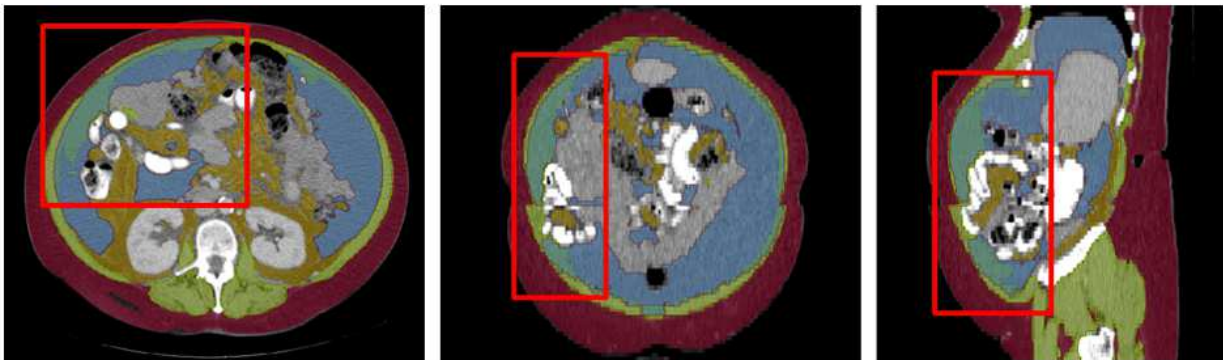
Example segmentations of subcutaneous fat, visceral fat, and muscle on a contrast-enhanced CT image of a 63-year-old female patient with ascites from TCGA-OV-AS. The scan was acquired with a 5mm slice thickness. Dice score of muscle and ascites was 0.106, denoting the highest over segmentation of approximately 800mL. Colors represent different tissues: red for subcutaneous fat, yellow for visceral fat, green for muscle, and blue for ascites. Red box highlights the area of over-segmentation of muscle and ascites, shaded in olive green.
